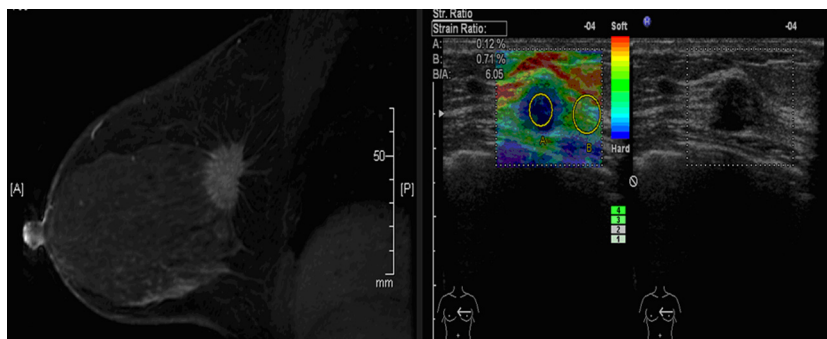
T size measured by MRI and US was inconsistent
